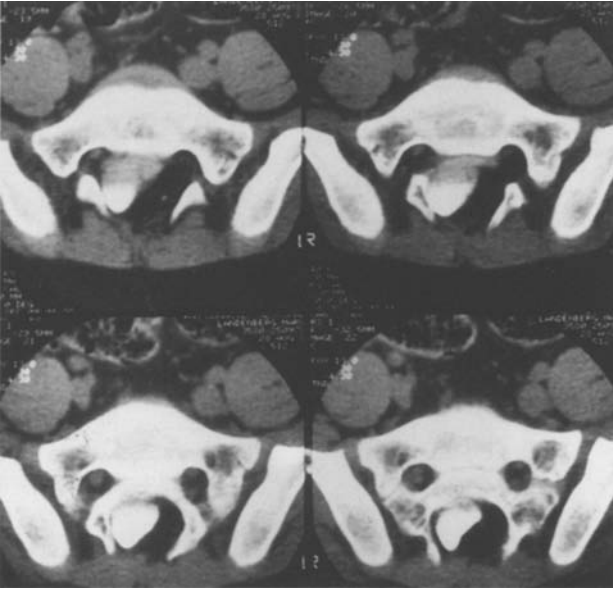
Lumbar myelo-CT of level L5/S1 with dyslocation of the distal lumbar column to right side in combination with spina bifida and lipoma in an 8 year old boy.
